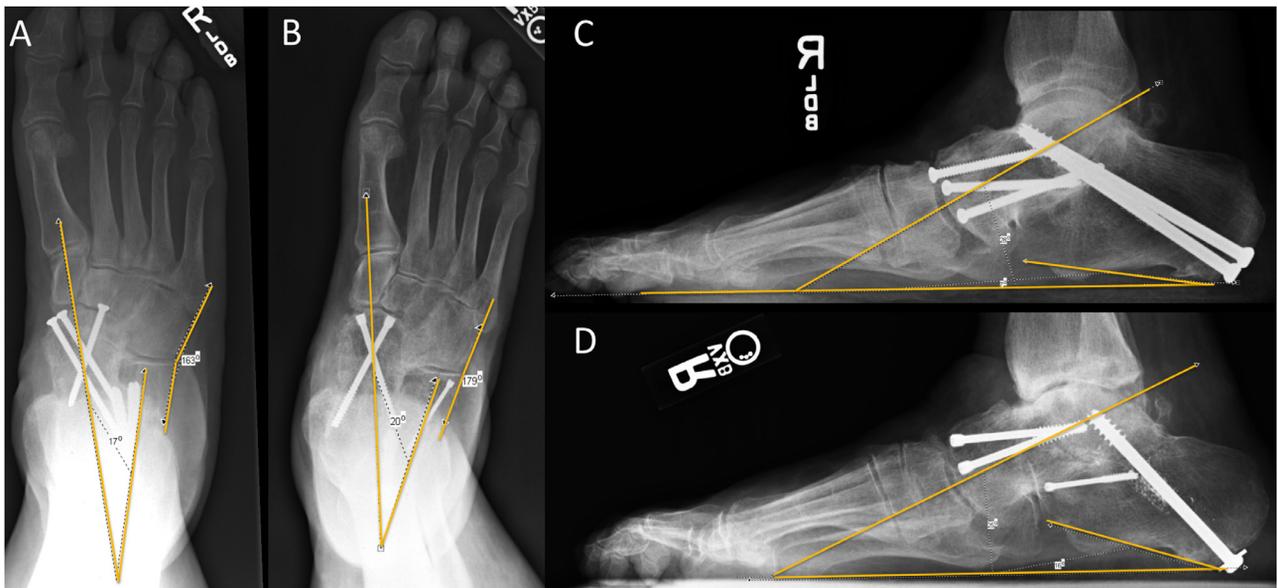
A 53-year-old male with a history of double arthrodesis 3 years earlier with residual flatfoot deformity. The patient underwent revision subtalar and talonavicular joint arthrodesis with adjunctive Evans calcaneal osteotomy. Anteroposterior preoperative (A) and postoperative (B) radiographs show correction in the transverse plane. Lateral preoperative (C) and postoperative (D) radiographs show correction in the sagittal plane.
